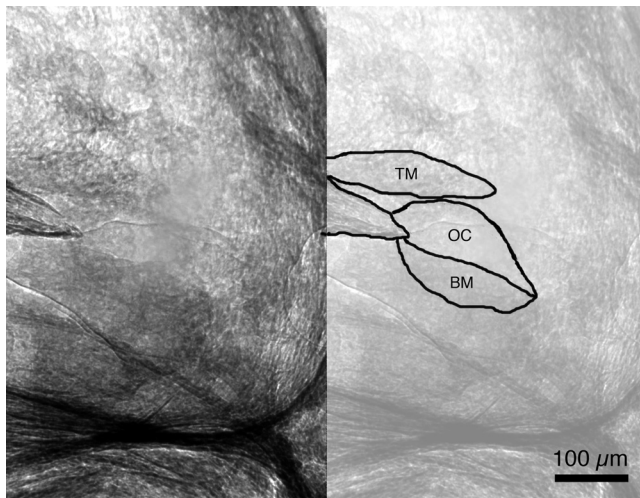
When largely ossified structures impede the view, fine structures cannot be identified. The outline of the tectorial membrane (TM), the organ of Corti (OC), and the basilar membrane (BM) can still be seen. Further improvements, such as partial tomography, will be used in the future to improve the image quality. Both panels show the same image, the right one with an overlay of the outlines of anatomical details. In particular, studies of cochlear morphology and cochlear physiology benefit from a noninvasive method to visualize tissue. Hard X-ray phase-contrast imaging provides such information.
